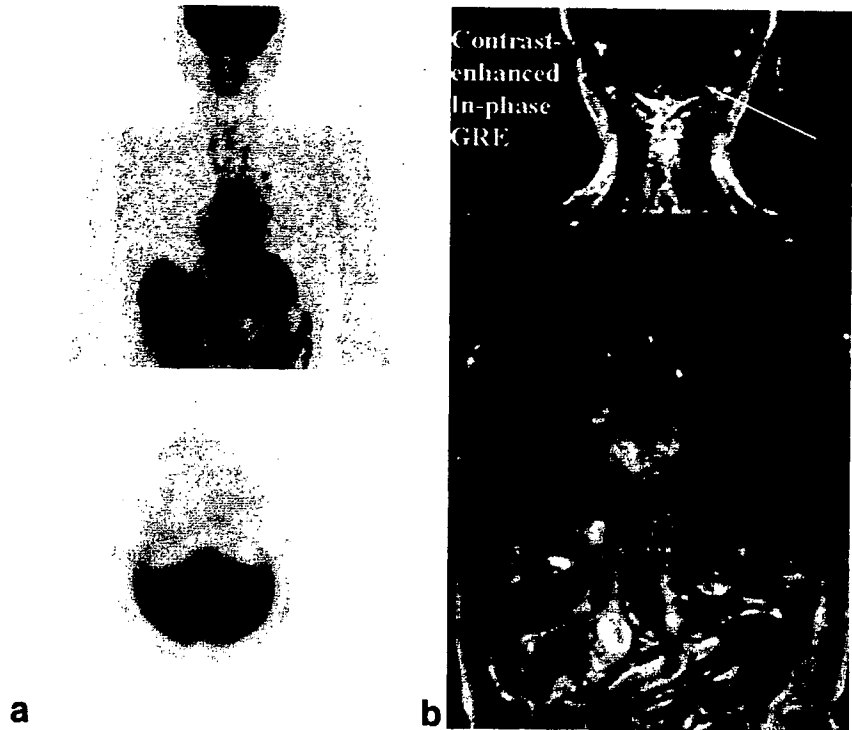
A 73-year old patient with adenocarcinoma and brain metastasis. a: Coronal and axial images of FDG-PET do not indicate a cerebellar metastasis. b: Whole-body MR imaging clearly demonstrates the presence of a cerebellar metastasis on a contrast-enhanced in-phase T1-weighted image (arrow).
